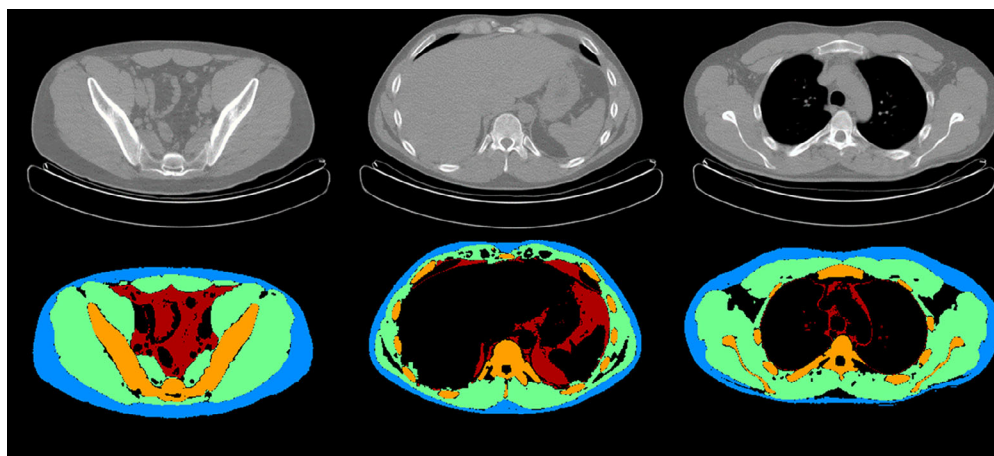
From left to right are sample axial slices selected from the Plv, Abd, and Thx aspects of the body torso in one subject. Both original low-dose CT images (upper row) and manually delineated masks of the four tissue regions of interest (lower row) are shown (where blue = SAT; red = VAT; green = Msl; orange = Sk). [Color figure can be viewed at [wileyonlinelibrary.com](http://wileyonlinelibrary.com)]
